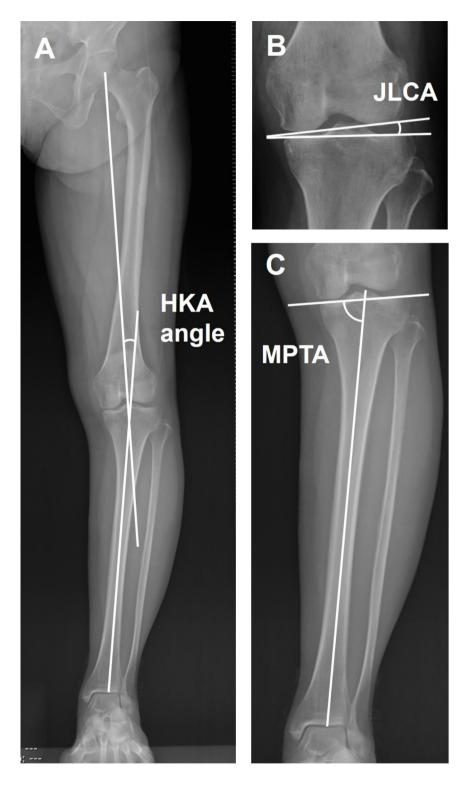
Radiographic measurements. (A) Hip-knee-ankle (HKA) angle. (B) Medial proximal tibial angle (MPTA). (C) Joint line convergence angle (JLCA)
